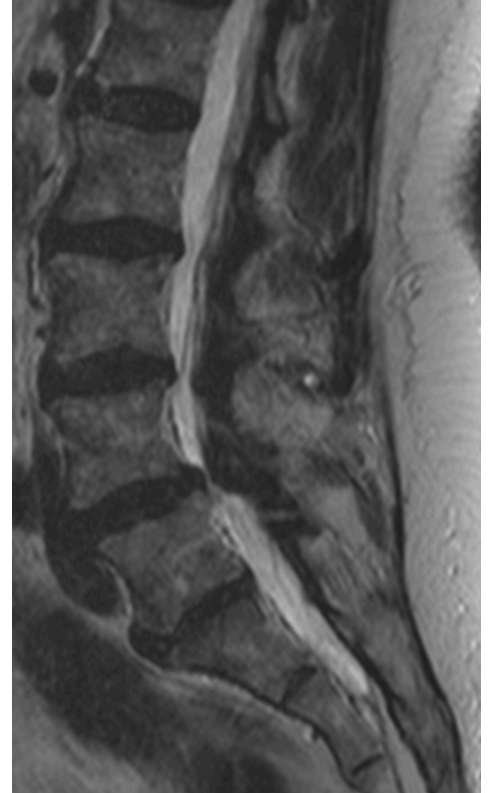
Midsagittal MRI view
